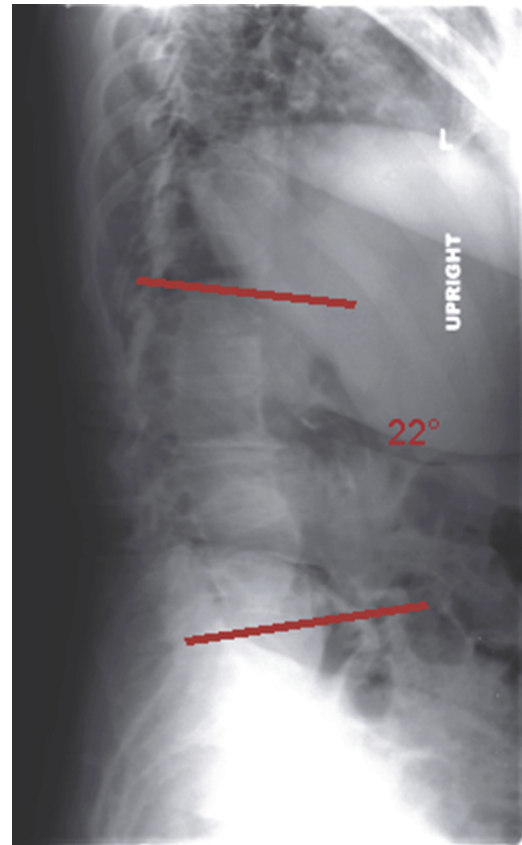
Preoperative upright lateral X-ray of lumbar spine demonstrating 22° kyphosis from L1–4.
